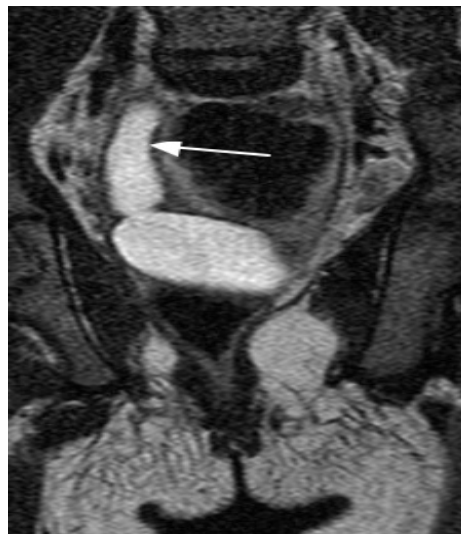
Coronal T2W MRI showing right unicornuate fluid filled uterus (hydrometra)
